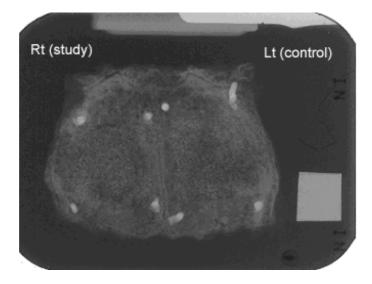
Radiograph taken at 6 weeks. The defect margin was little difficult to detect. The radiopaque area of bone graft materials were observed. The radiograph in the experimental site was showed a radiopacity as well as the control site, but the in 6 weeks were showed greater radiopacity than 4 and 2 weeks, respectively.
